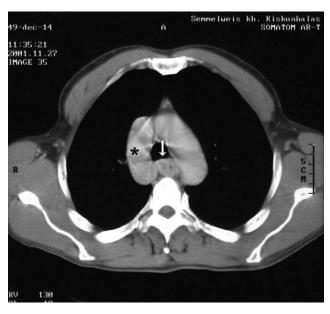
The CT scan demonstrates a mid-esophageal mass with the invasion of the trachea (arrow) and the presence of mediastinal lymphadenomegaly. Images also prove dilated azygos vein and arch in their paravertebral course (asterisk). In conjunction with an undetectable inferior vena cava, the diagnosis of azygos continuation was made.
